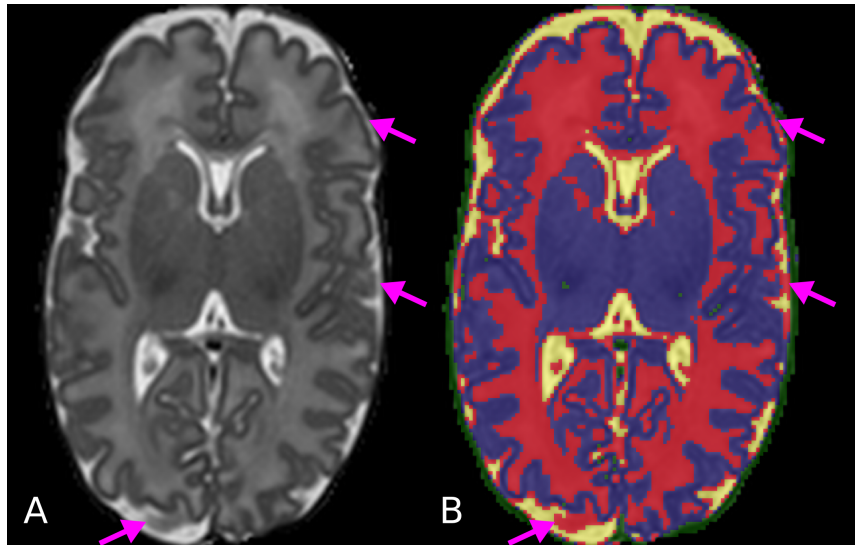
CSF-WM PV evident in the CSF-CGM boundary. A neonatal T2 MR image acquired at 36 weeks PMA (A) is split into tissues types (yellow:CSF, red:WM, blue:GM, green:background) with intensity clustering (B). The arrows point areas where the partial volume of CSF and CGM results in similar intensities to the WM.
